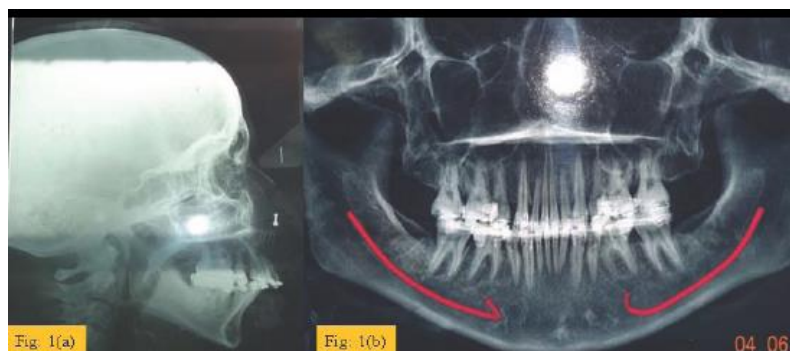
Preoperative lateral cephalometric and panoramic radiograph
